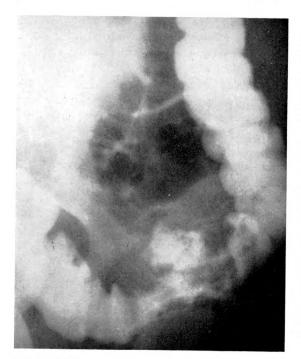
Oblique roentgenogram of barium-filled sigmoid showing a large ulcer crater with localized narrowing of the colon in this region.
